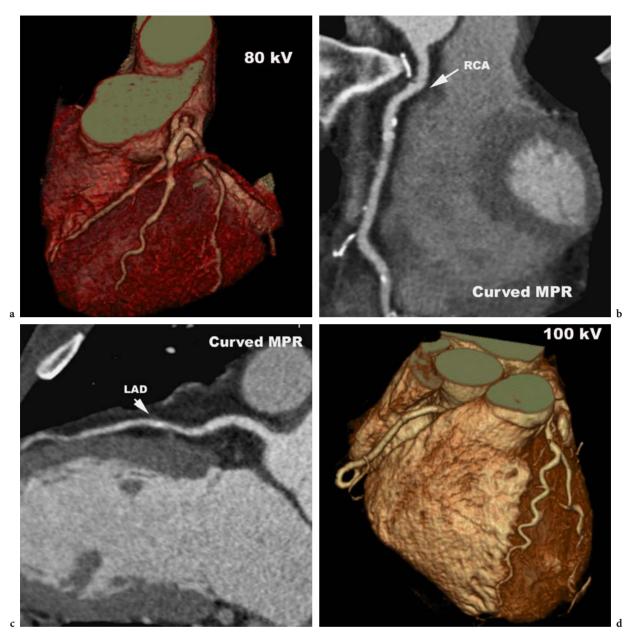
Example of curved multiplanar reformatted images (b,c)and 3D coronary image (a) in a 36-year old heart transplant patient obtained at 80 kV and 700 mAs, using a 64-slice CT. Patient was 60 kg with a noise measured at 12 Hounsfield Units (HU) on the pre-control image. DLP of contrast-enhanced acquisition was 148 mGy·cm, accounting for an estimated dose of 2.5 mSv. d Example of a 3D coronary image in a woman presenting with atypical chest pain: noise was found at 18 HU and images were acquired at 100 kV and 700 mAs, using a 64-slice CT. Patient was 55 kg. DLP was 246 mGy·cm corresponding to a radiation dose of 5 mSv. In both cases image quality was found satisfactory for diagnosis
